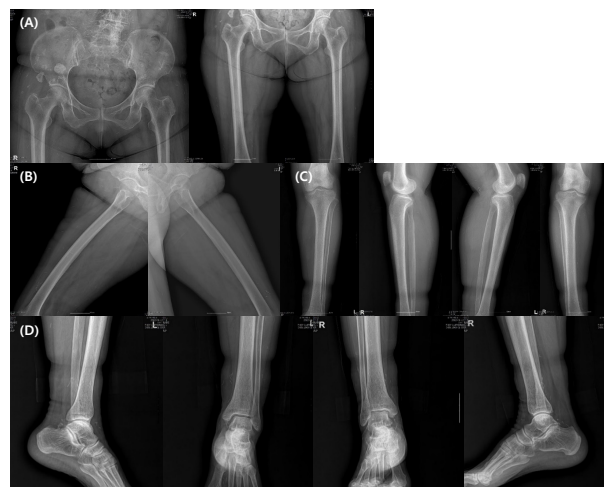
X-ray scan of the leg. (A) pelvis; (B) femur; (C) tibia; and (D) ankle.
